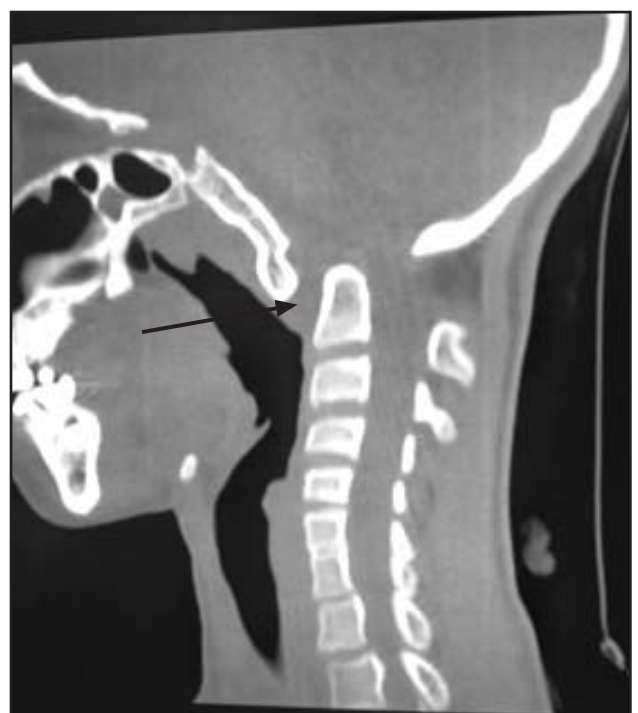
CT Sagittal reformat Bone window Increased atlantodens distance.
